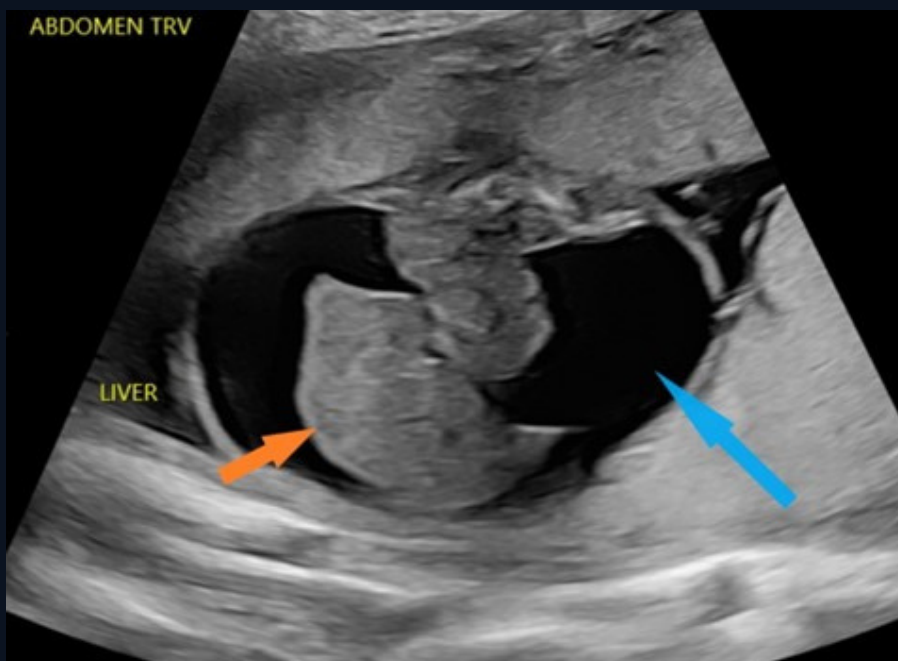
This axial greyscale ultrasound image demonstrates the normal liver (orange arrow) surrounded by large volume ascites (blue arrow).
